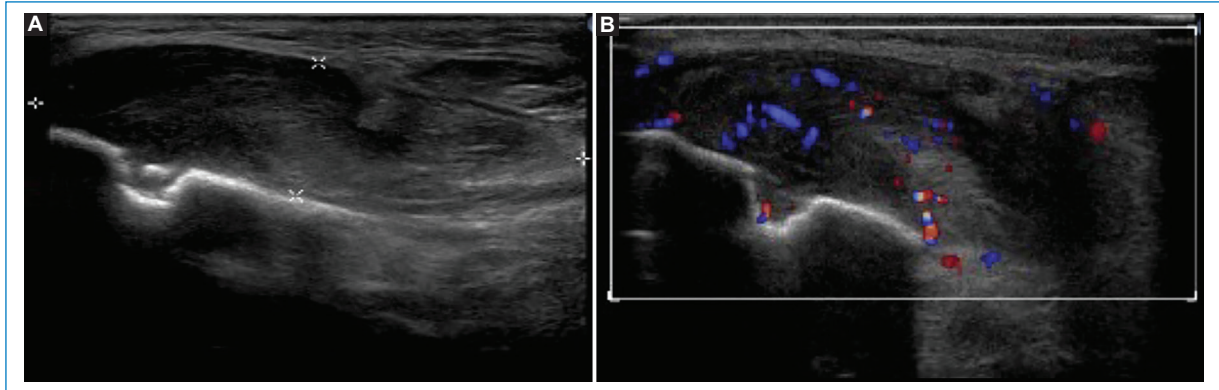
Foreign body lesion. A: the ultrasound shows an irregular, poorly defined, heterogeneous collection with cystic and other echogenic areas. B: color Doppler also shows a foreign body (hypoechoic with shadow), with the presence of bubbles (hyperechoic path) and perilesional hyperemia with hyperflow.
